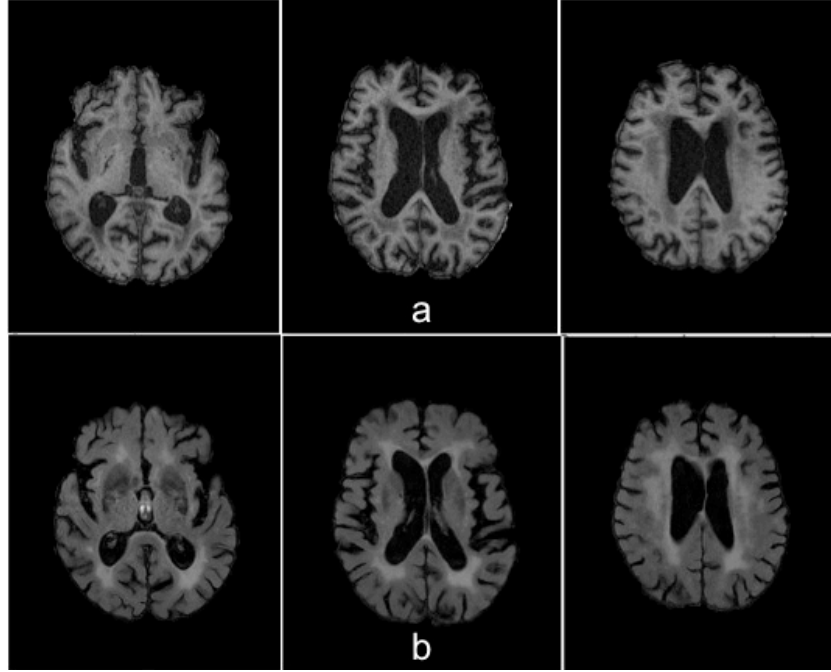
The T1-weighted MR brain image (a) and T2-weighted FLAIR image (b) with severe white matter hyperintensities due to demyelination in an elderly subject.
